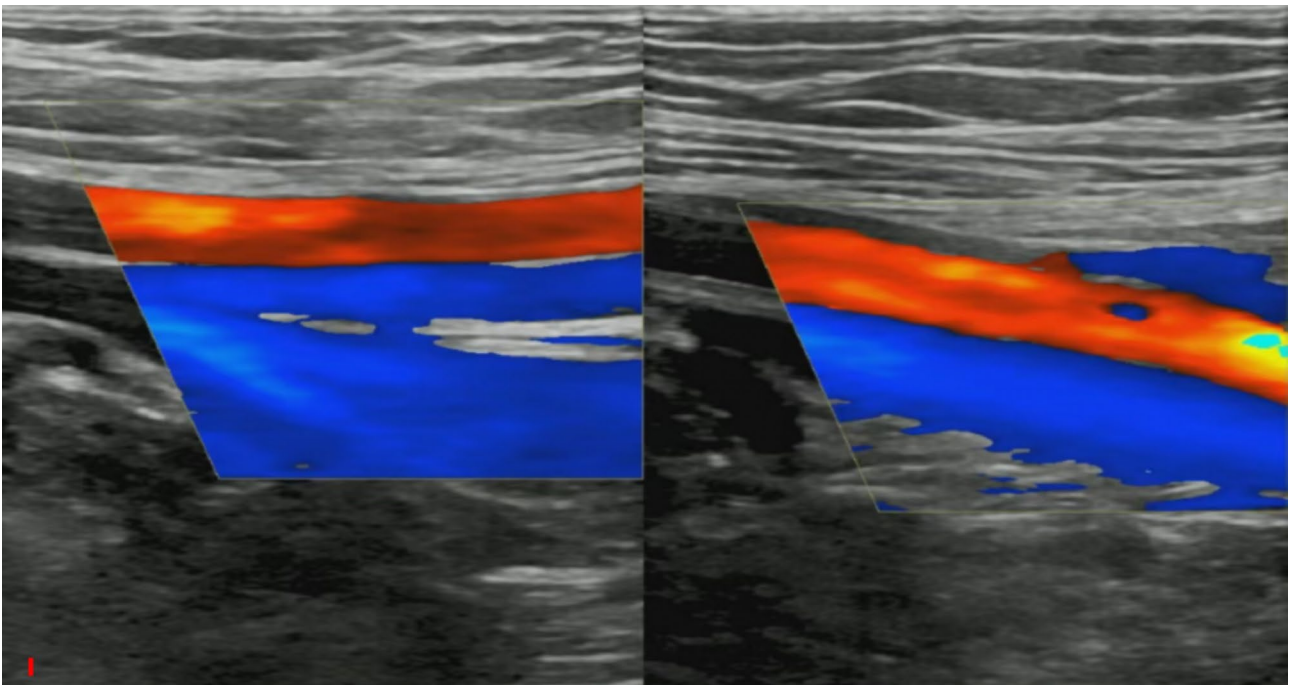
Thrombus sonogram. Note: A 66-year-old man who underwent postoperative color Doppler ultrasound of lower limb veins was found to have left intermuscular venous plexus thrombosis
